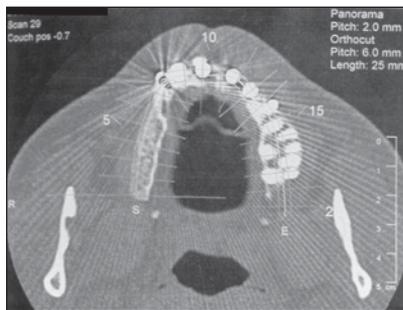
CT imaging before reconstruction. Pronounced atrophy of the alveolar ridge can be observed.
